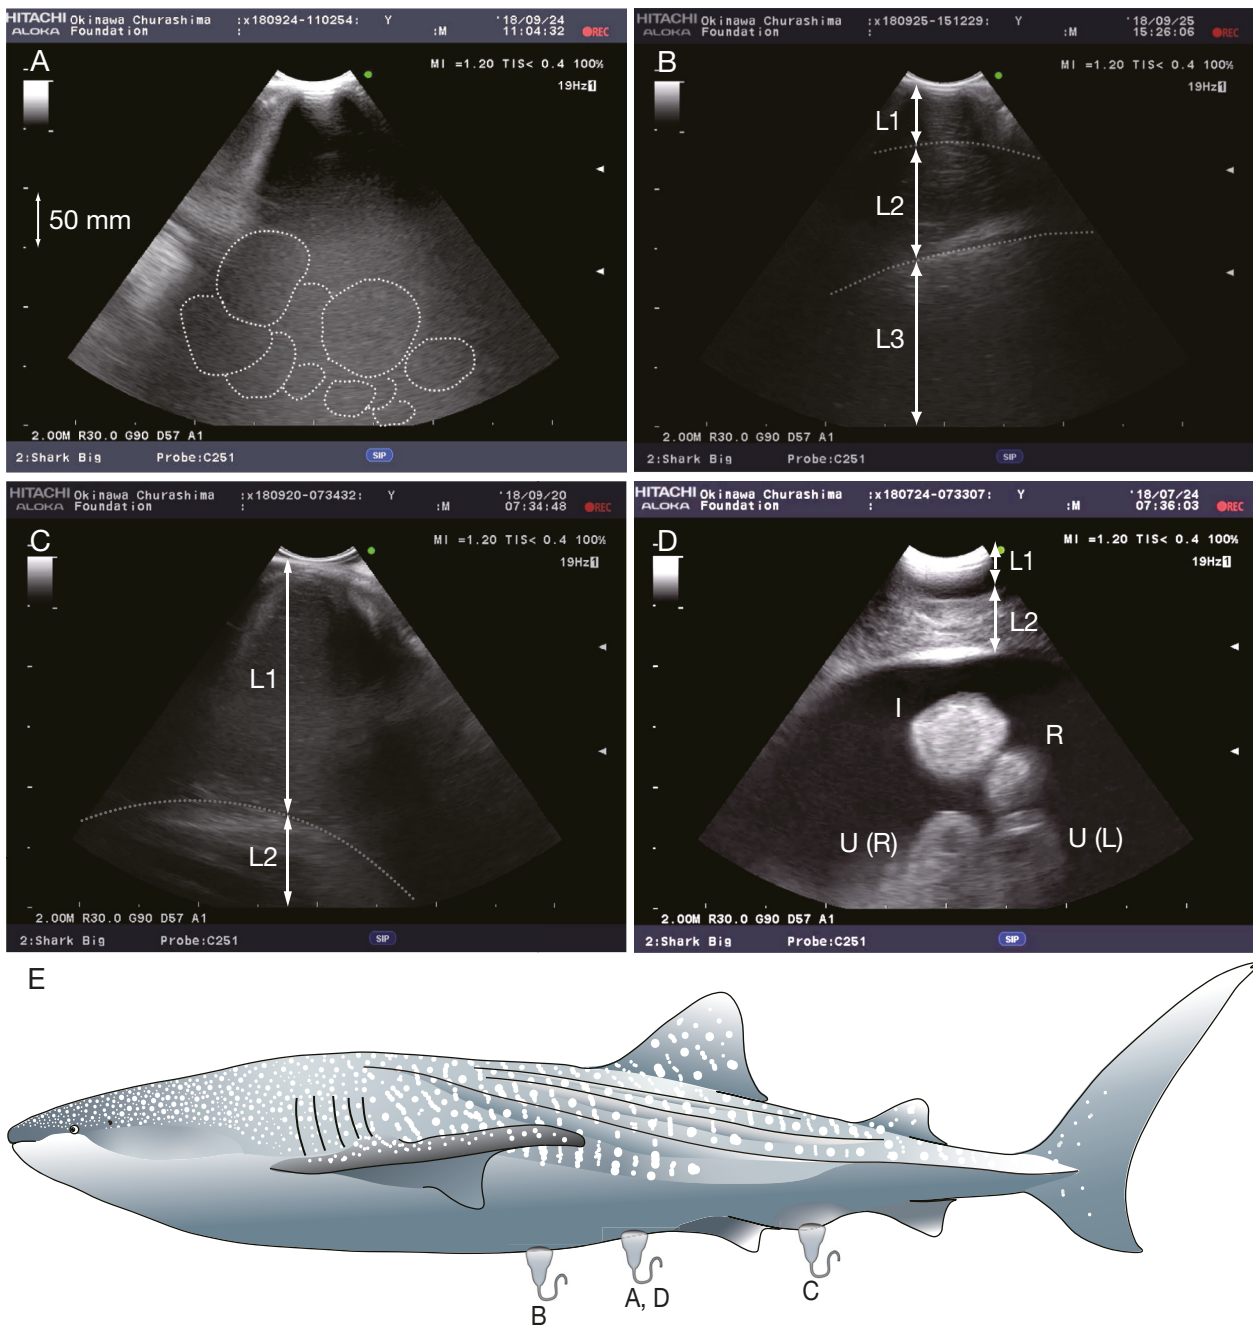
(A–D) Ultrasound images taken from female whale sharks in the Galapagos. (A–C) Mature females. (A) Longitudinal plane of ovarian follicles enclosed in dotted lines. (B,C) Transverse plane. (D) Transverse plane in an immature female in the Okinawa Churaumi Aquarium (OCA). (E) Parts of the body where each scan was performed. Green marker (pointer) next to the top right of each sonogram consistently points cranially in longitudinal scans or to the left in transverse scans. MI and TIS in the upper right corner of each image indicate the mechanical index and soft-tissue thermal index, respectively. Scale resolution on the lateral column in each image indicates 50 mm of ultrasound penetration depth. ‘W-shaped’ anechoic to hypoechoic shadow (artifact) emanates immediately proximal to the area of hyperechoic enhancement directly beneath the probe in (A) and (B). L1: skin layer; L2: muscle layer; L3: liver; I: intestine; R: rectal gland; U(R): right uterus; U(L): left uterus
